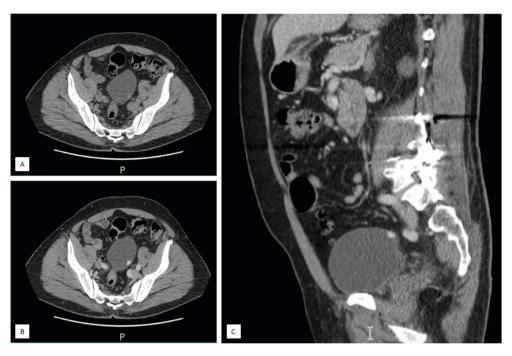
CT of the abdomen and pelvis demonstrating a single enhancing intraluminal bladder tumor A-B. Pre- and post-contrast axial cuts. C. Post-contrast sagittal cut.
